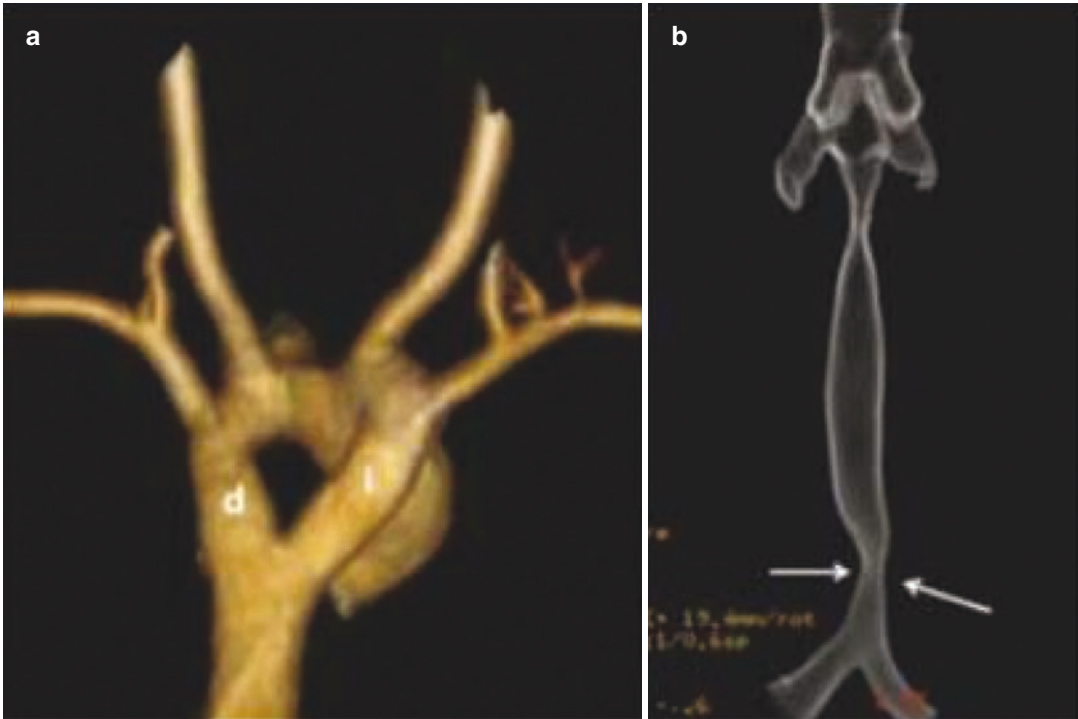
Vascular ring in a 4-month-old patient with a congenital stridor, shown on multidetector helical CT scans with three-dimensional reconstruction. (a) An anteroposterior view shows a double aortic arch (d: right
